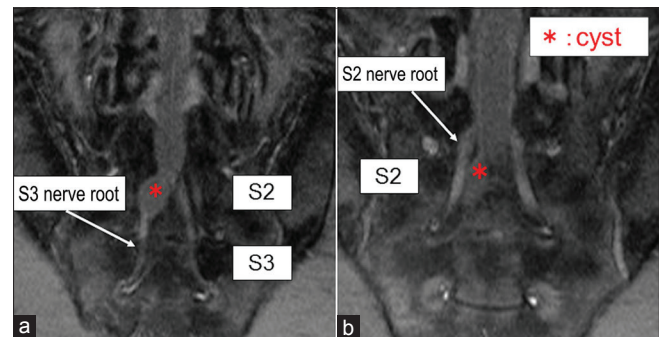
The relationship between the cyst and the nerve roots. (a) Coronal fat-suppressed T2-weighted imaging shows that the cyst (asterisk) likely originated from the right S3 nerve root. (b) The cyst compresses the right S2 nerve root
